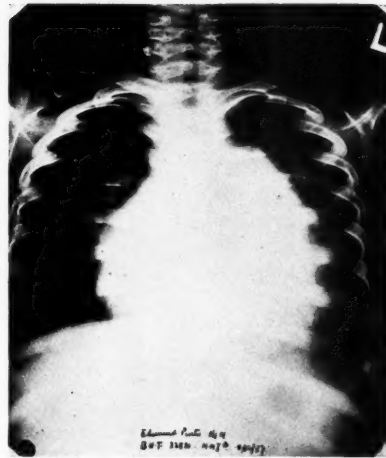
X-Ray: Antero-posterior view of heart showing enlargement of right side of heart and left auricle
